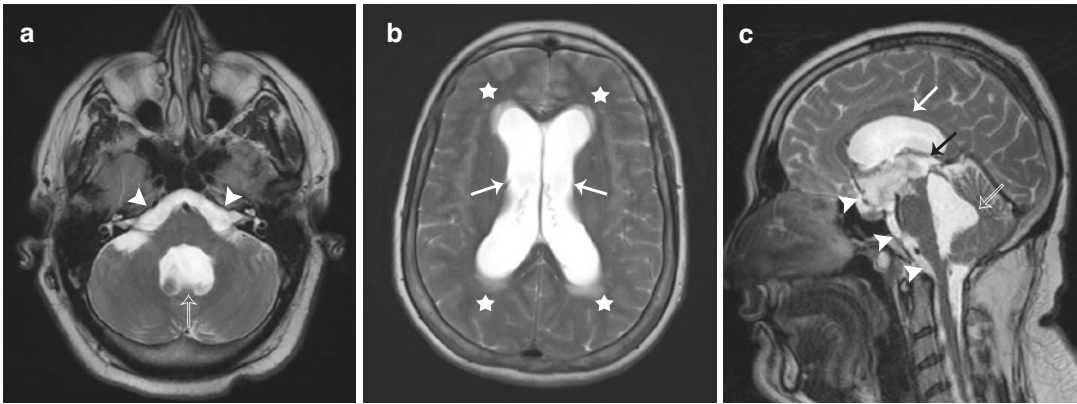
Communicating hydrocephalus due to inflammatory exudates in the basal subarachnoid cisterns. (a and b) Axial and (c) sagittal T2-W MR images show dilatation of the lateral ventricles (white arrows), third ventricle (black
